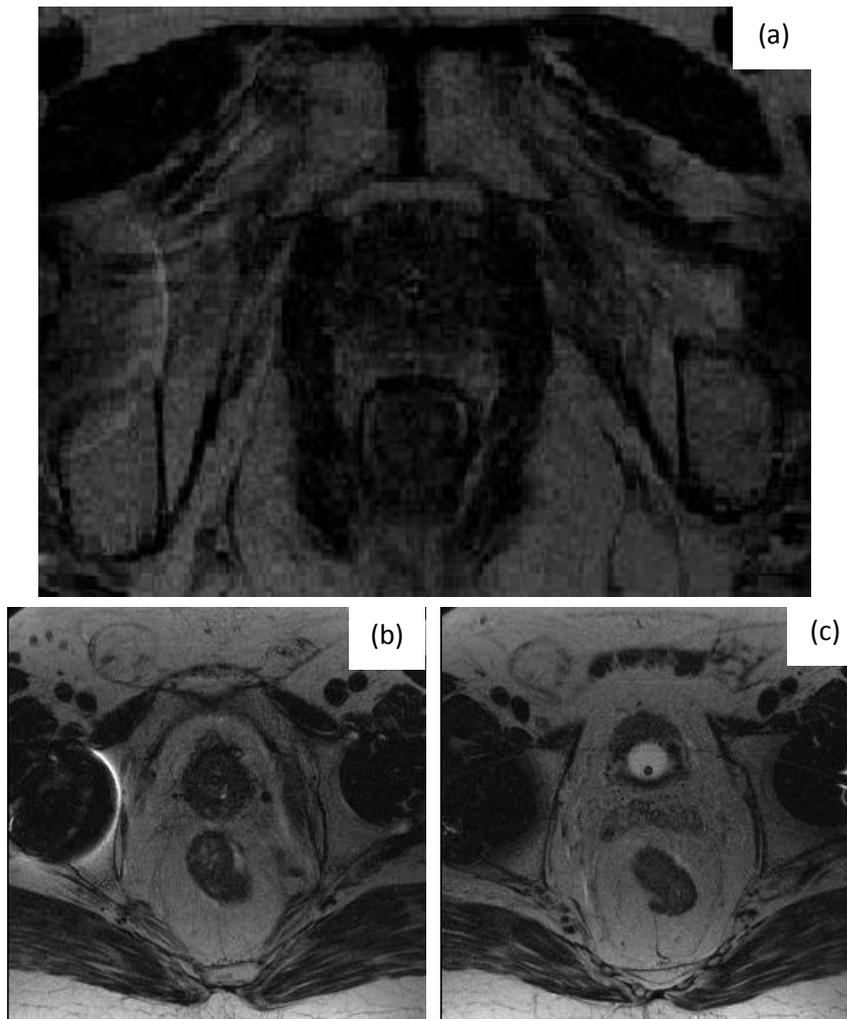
MR images from patient #3 (a) transverse plane towards prostate base, (b) and (c) towards distal end of plastic needles. Prostate near image centre. Needles visible as small black dots (signal void) in prostate. T2 TSE, 904 ms TR, 102 ms TE, COL phase encoding direction, 150° flip angle, 3 mm slice thickness. Bandwidth 515 kHz.
